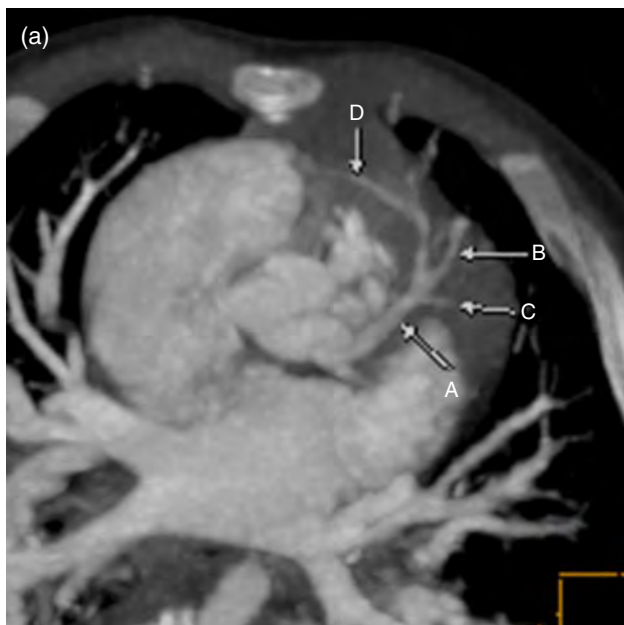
Axial maximum intensity projection (MIP) and frontal color-coded 3D images from a cardiac CT shows a single left coronary artery (A) arising from the left coronary sinus with the circumflex (C), left anterior descending (LAD) (B), and right coronary (D) arteries all arising from the left coronary artery. Notice that the right coronary crosses in front of the narrowed right ventricular outflow tract (E). The surgeon would need to be notified of this finding before surgery to plan the best approach.
